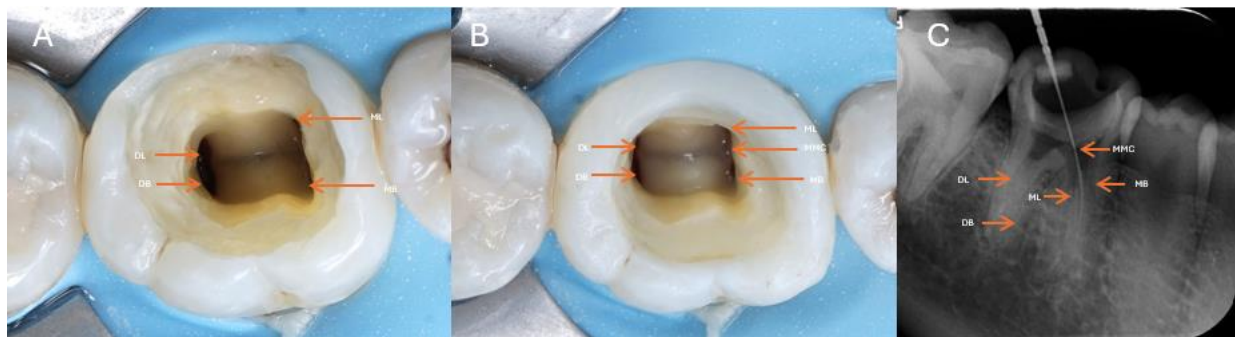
(A) Initial access revealed two mesial canals and two distal canals. (B) a developmental groove between MB and ML suggested an MMC, which was confirmed to be using DG-16 explorer (Hu-Friedy, Chicago, USA) and micro-opener (VDW, Munich, Germany). (C) MMC confirmed radiographically with SLOB technique using C-Pilot file #8
